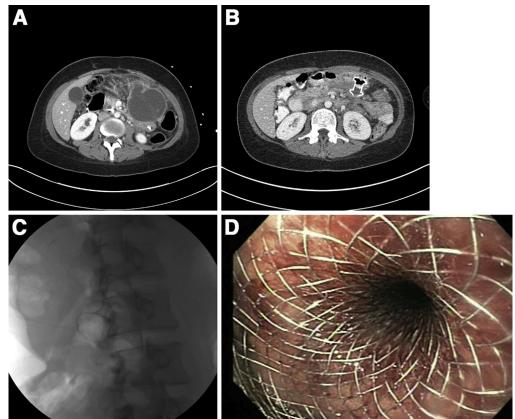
LAMS for drainage of a pancreatic pseudocyst. (*A*) CT image of pseudocyst fluid collection. (*B*) CT image after deployment of a LAMS. (*C*) Fluoroscopic image of stent. (*D*) Endoscopic image of the gastric lumen side of the stent.
